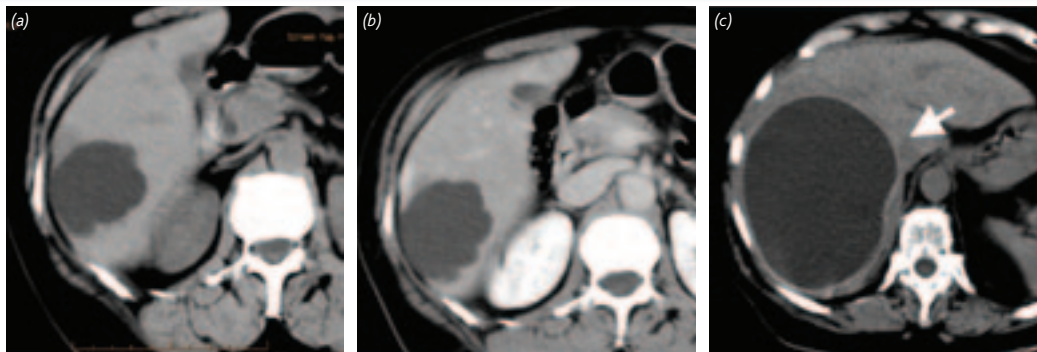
Differential diagnosis of cystic lesions by CT. (a) and (b) Simple biliary liver cyst with the absence of a definite wall and lack of enhancement. (c) Type I hydatid cyst showing subtle calcifications within the peripheral wall (arrow)
